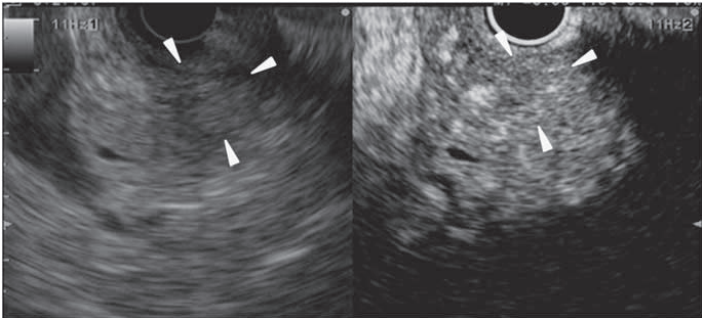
A typical example of a solid lesion with isoenhancement (in this case, an inflammatory pseudotumor). Conventional endoscopic ultrasonography (EUS; left) shows a hypoechoic area (arrowheads) at the pancreas head. Contrast-enhanced harmonic endoscopic ultrasonography (CH-EUS; right) indicates enhancement in this area similar to the surrounding tissue; a margin is not observed.
